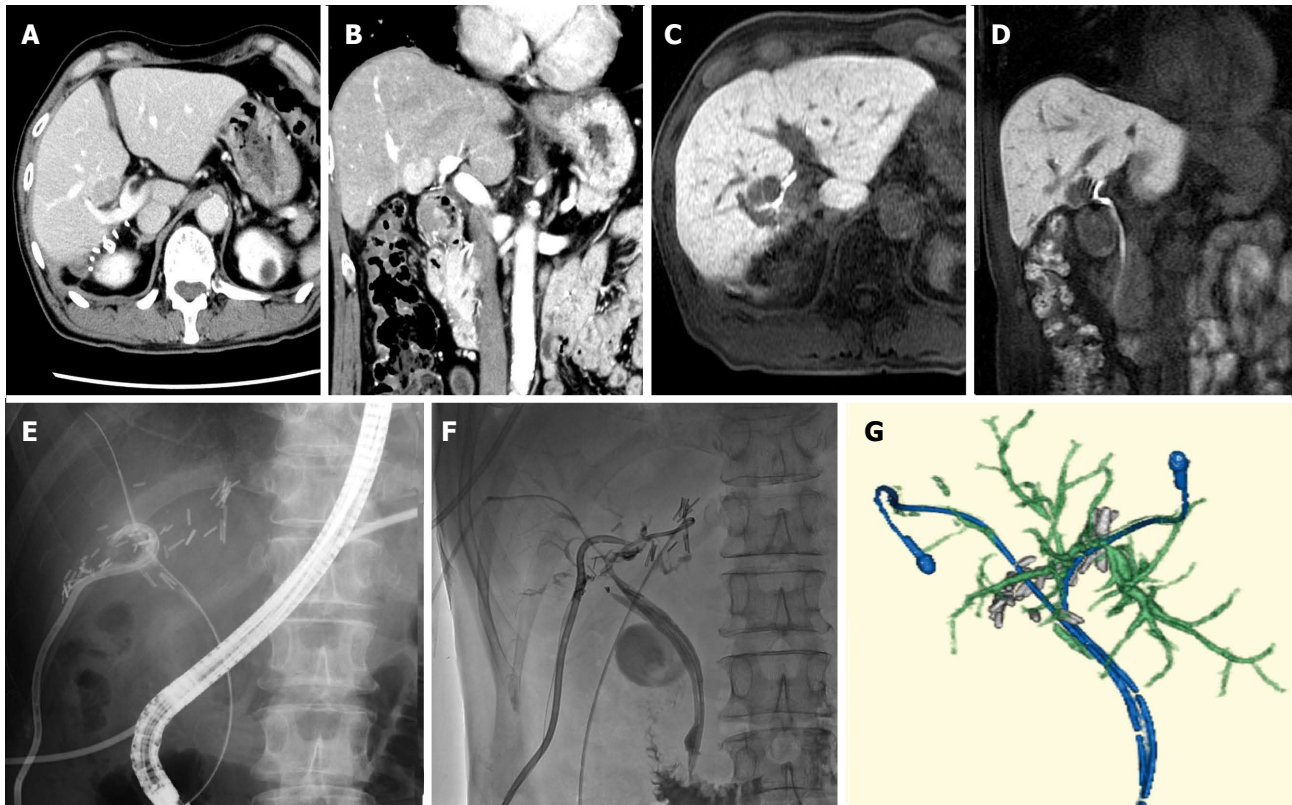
Representative grade C case in bile leakage. A 67-year-old man had hepatocellular carcinoma (diameter: 2 cm; A: Axial view; B: Coronal view) in segment S5 of his liver (located at the bifurcation of the bile duct in the hilar plate) (C: Axial view; D: Coronal view). The tumor was resected via enucleation; E: Bile leakage was detected and so endoscopic retrograde cholangiodrainage was performed together with percutaneous drainage of the resected pouch; F: Subsequently, stenosis of the left hepatic duct due to bile duct ischemia occurred. Percutaneous transhepatic cholangiodrainage was performed via the B3 duct; G: Three-dimensional reconstruction based on CT images obtained before the patient was discharged from hospital. CT: Computed tomography.
